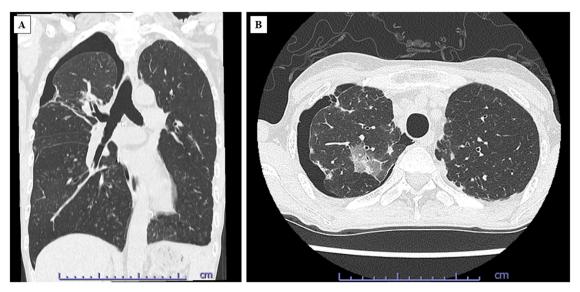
Finding of computed tomography (CT). (A) Coronal section. (B) Axial section. Chest CT shows a mild right pneumothorax and a ground-glass opacity in the right upper lobe without a cavity lesion. Bronchiectasis due to diffuse panbronchiolitis was bilaterally observed.
